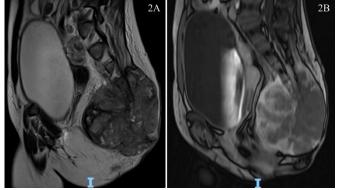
Preoperative examination. (2A) Sagittal T2-weighted MRI showing an expansive lesion with small areas of hyperintensity in the lumbosacral spine with invasion of adjacent structures: lobulated appearance of the lesion and multiple hypointense septa. (2B) Sagittal gadolinium T1-weighted MRI reveals a "honeycomb" pattern of the septa, with hypodense areas of necrosis or mucus.
